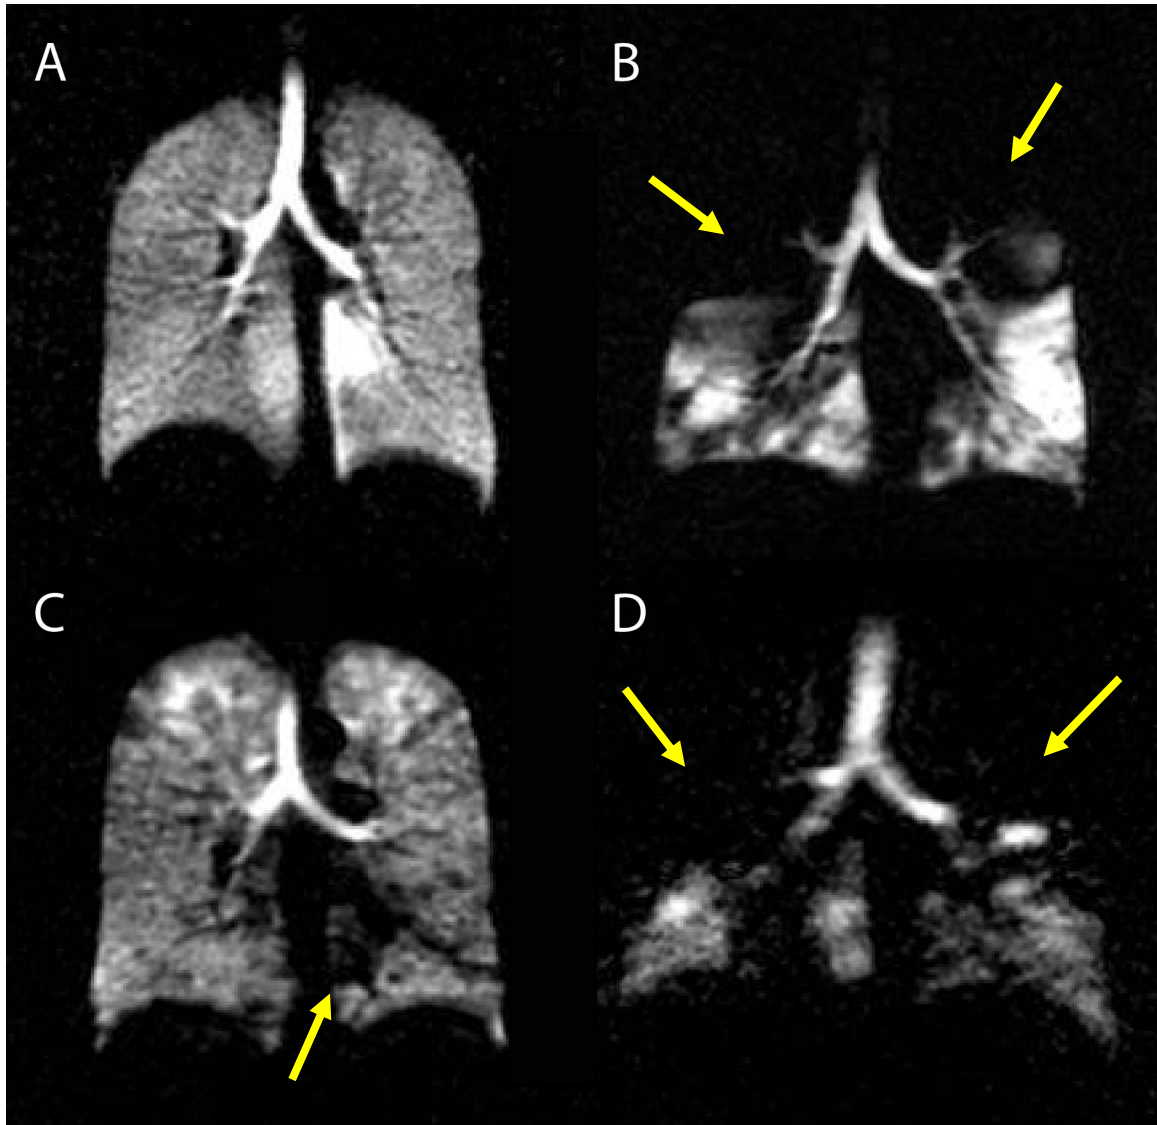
Hyperpolarized ^{129}Xe MRI images
